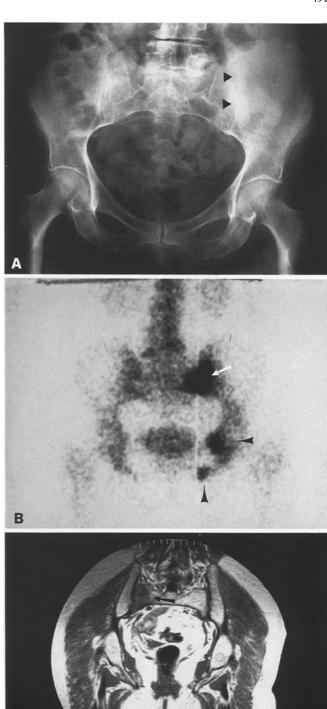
Sacral insufficiency fracture in a patient with low back pain and clinical suspicion of metastatic disease. A Plain radiograph of pelvis demonstrates sclerosis about the left sacroiliac joint (arrowheads). This finding was interpreted as degenerative disease or possibly osteoblastic metastasis. B Nuclear bone scan with three areas of increased activity consistent with fracture or metastasis but not diagnostic (white arrow, black arrowheads). C Coronal T₁-weighted MR image demonstrates vertically oriented low signal band along sacral aspect of left sacroiliac joint (arrow), highly suggestive of an insufficiency fracture. This nonspecific finding led to a bone biopsy which demonstrated a fracture
